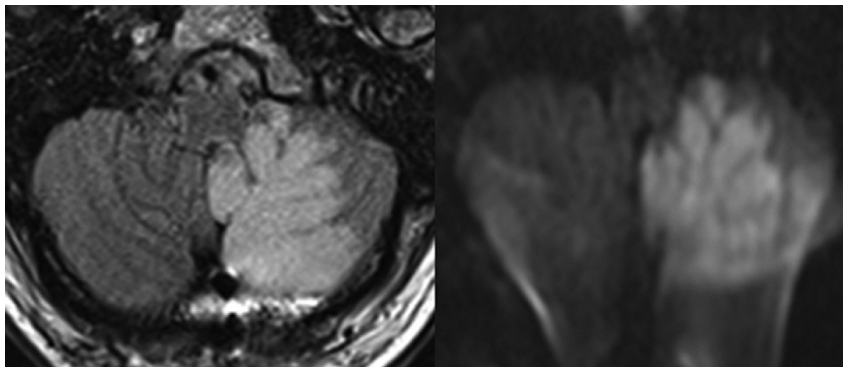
(Left and Right) Diffusion weighted magnetic resonance imaging axials with acute left inferior cerebellar and small right parietal lobe infarcts in the distribution of the left posterior inferior cerebellar artery.
